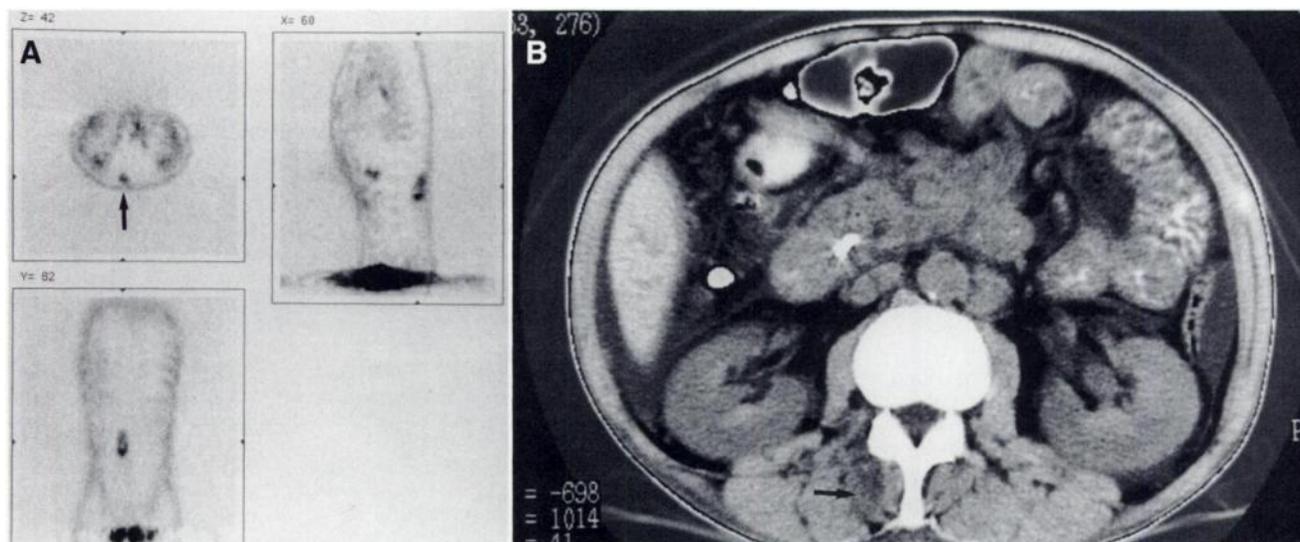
PET images without attenuation correction (A) and CT scan (B) of 50-y-old man, known alcohol and drug abuser, who presented with right upper quadrant pain and worsening back pain. PET images (transverse, top left; coronal, bottom; sagittal, right) show uptake in pancreas consistent with malignant lesion (not shown) but also show focus of increased FDG uptake in right paravertebral muscle (arrow). When first interpreted, CT scans showed enlargement of pancreas, intrahepatic biliary tree dilatation and dilatation of common bile duct. Only retrospective examination of CT scan revealed necrotic lesion in that location (arrow). Percutaneous biopsy revealed metastasis.
